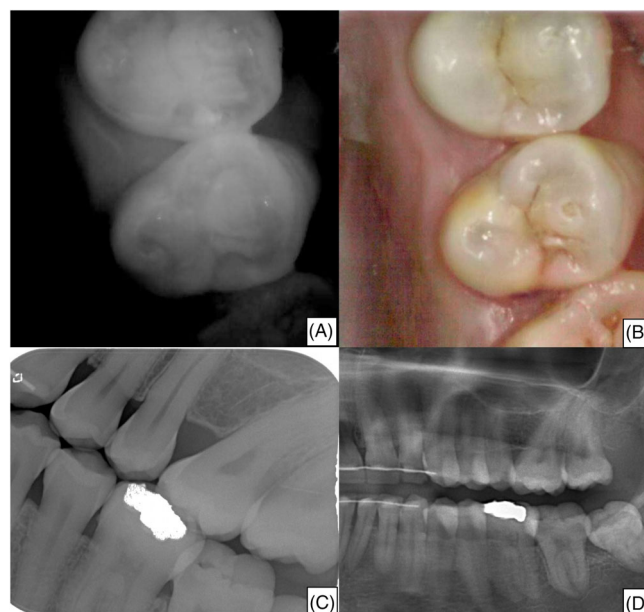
(A) IOS image with near-infrared imaging featuring. (B) Colored IOS screen. (C) Bitewing radiography. (D) Panoramic radiograph of teeth 2.4 and 2.5.
